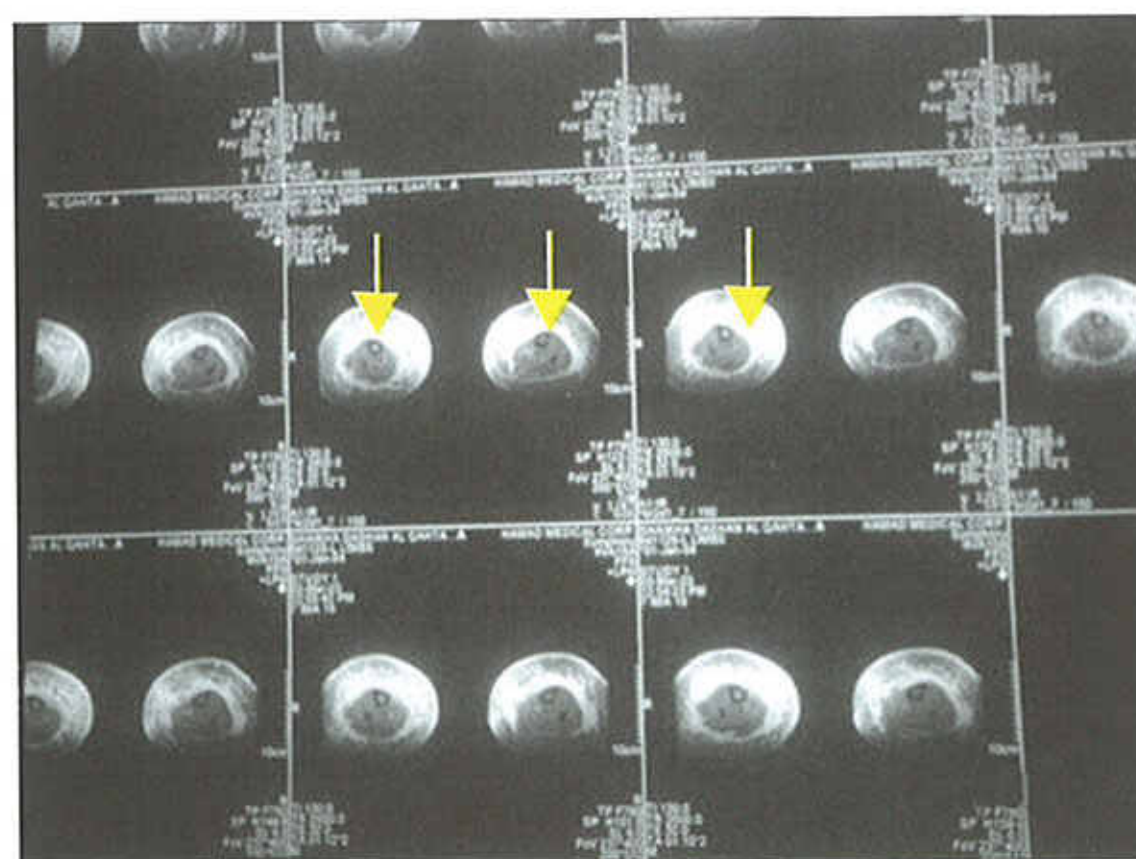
MRI. Multiple foci of cystic dilatation of lymphatic spaces at the lymphangioma circumscriptum site..
